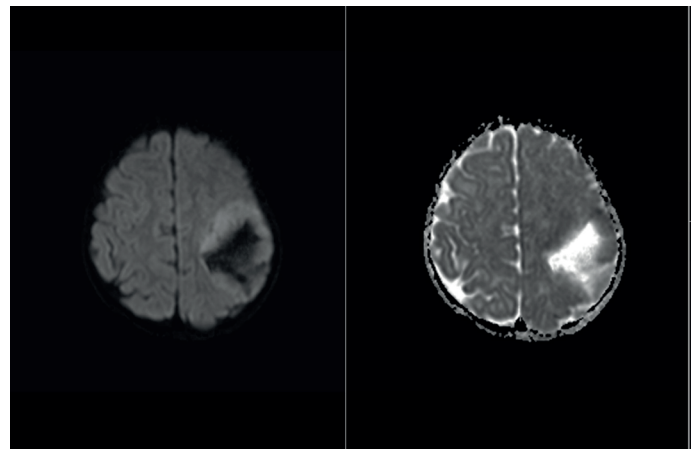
Diffusion-weighted image (DWI).
